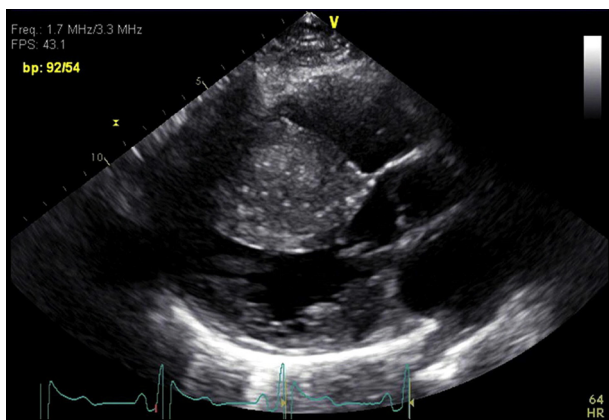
Parasternal long-axis view of the preoperative transthoracic echocardiogram (A) demonstrated a small left ventricular cavity with a maximum septal thickness of 48 mm (*double-headed arrows*). The LV cavity was significantly enlarged after transapical myectomy (B). Ao, Aorta; LV, left ventricle; LA, left atrium.
